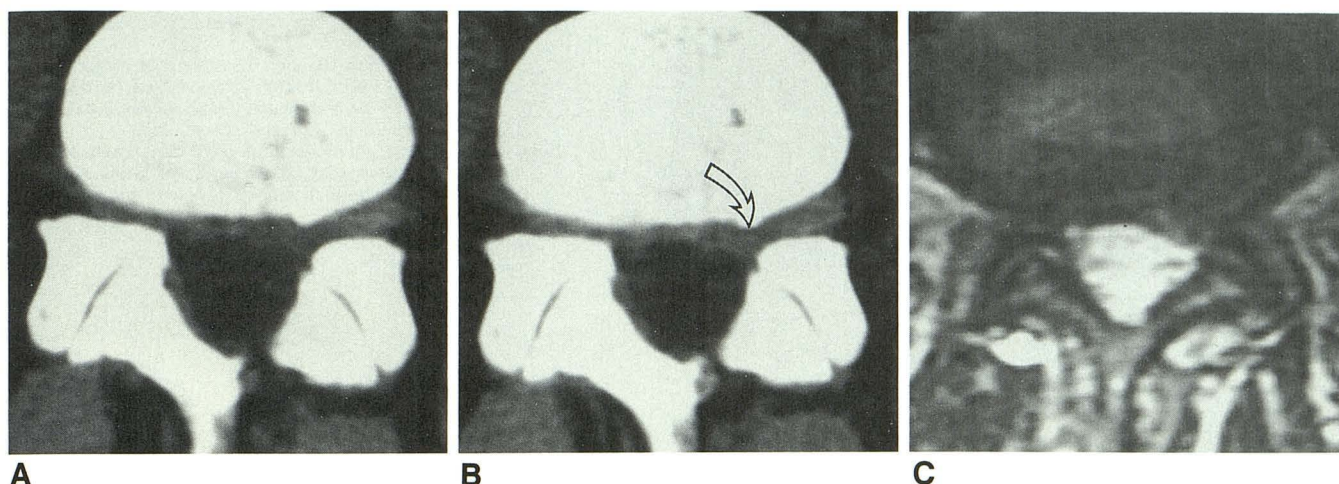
Case 7: Subligamentous free herniated nucleus pulposus (HNP) and epidural scar, L4–L5. A and B, Unenhanced (A) and bolus contrast-enhanced (B) CT scans. Free HNP enhances centrally (arrow), along with peripheral enhancement secondary to scar and posterior longitudinal ligament. C, Long TR/TE (2500/80) sequence. Free HNP appears with grade 3 intensity. Mass effect is more obvious than on CT.
